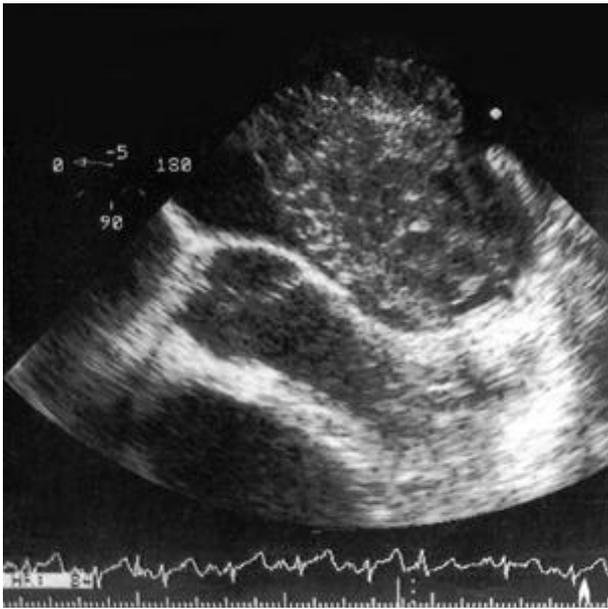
Echocardiography reveals a free floating, large, pedunculated tumor attached to lateral wall of left atrium.
